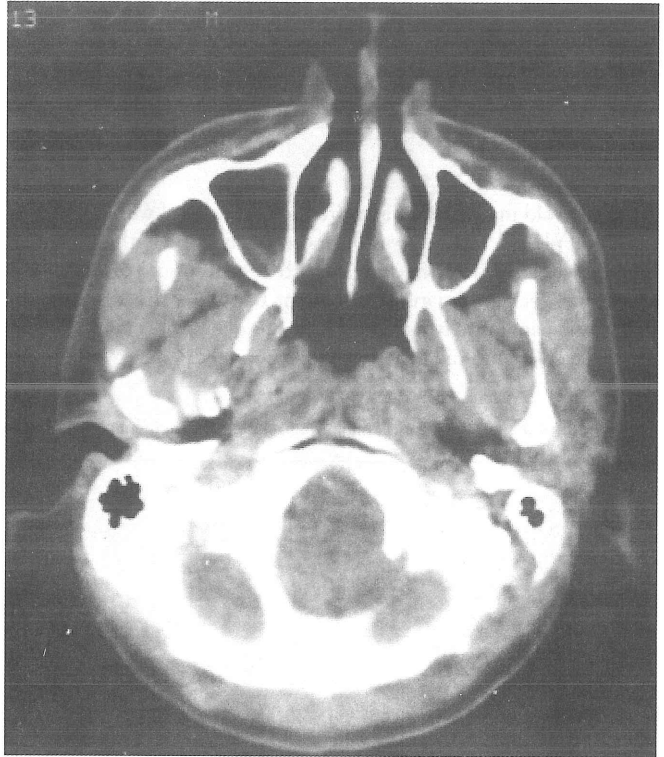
Normal nasopharyngeal computed tomography.
